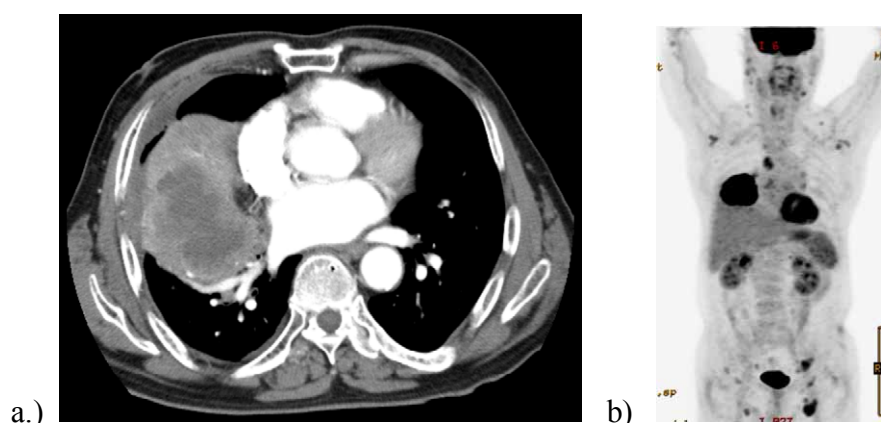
CT CT chest scan (a) and whole body FDG-PET scan (b) of the patient. About 9.5 cm sized huge lung mass with central necrosis was detected in right lower lobe and the mass had a hypermetabolic walled cavity. Multiple metastatic lesions were also showed in both of neck, axillas, inguinal regions and mediastinum including right hilum
